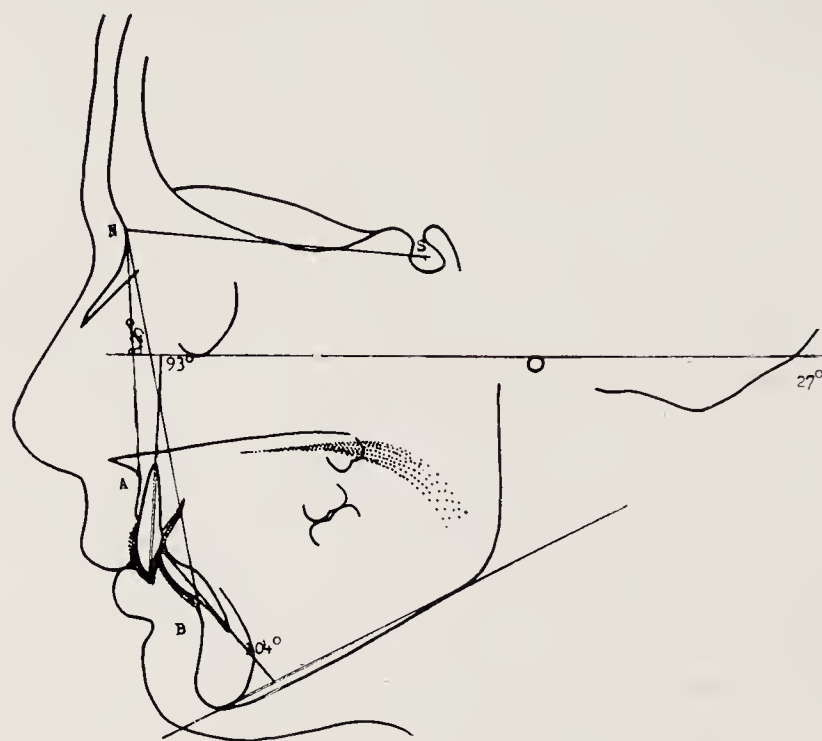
Tracing from lateral radiograph at "mylohyoid phase" of swallowing with barium paste.
